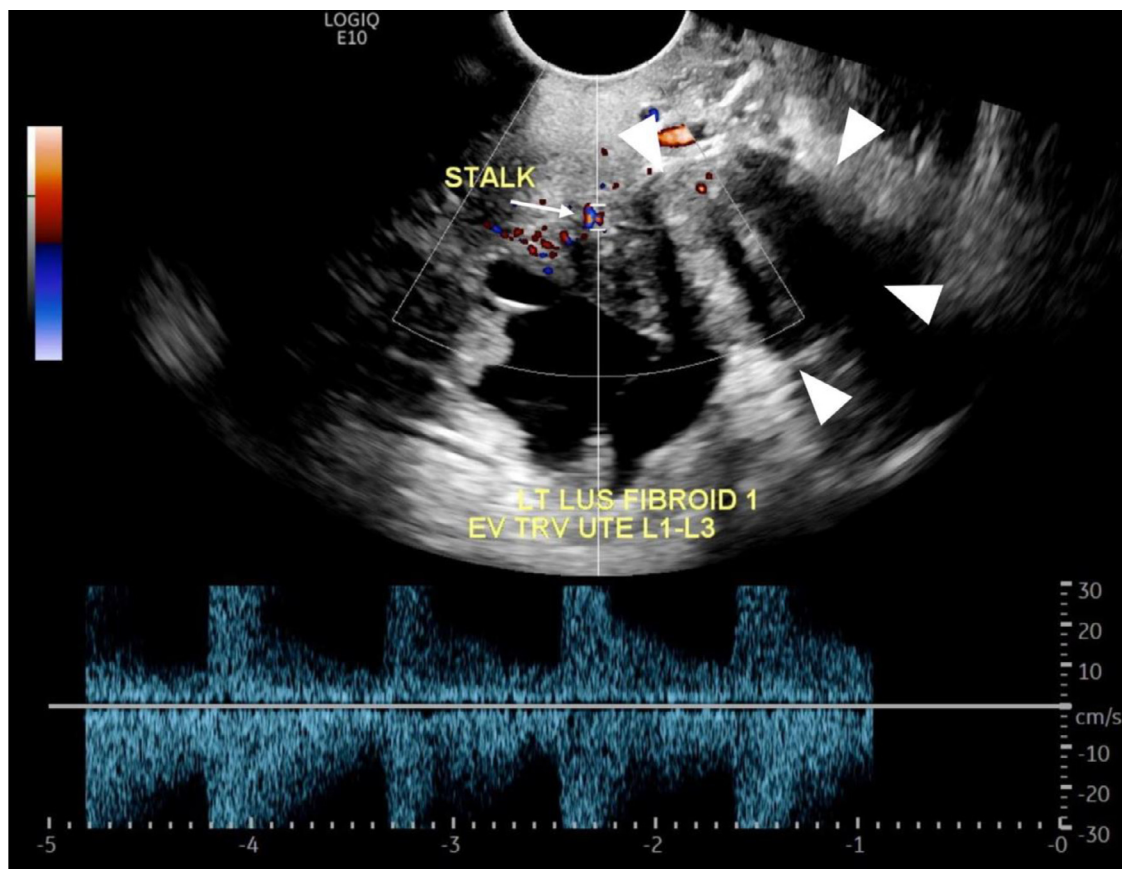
Single pelvic ultrasound in different patient for comparison with a pedunculated fibroid clearly shows Doppler flow within the stalk (arrow) and within the fibroid (arrowheads), with spectral waveform.
